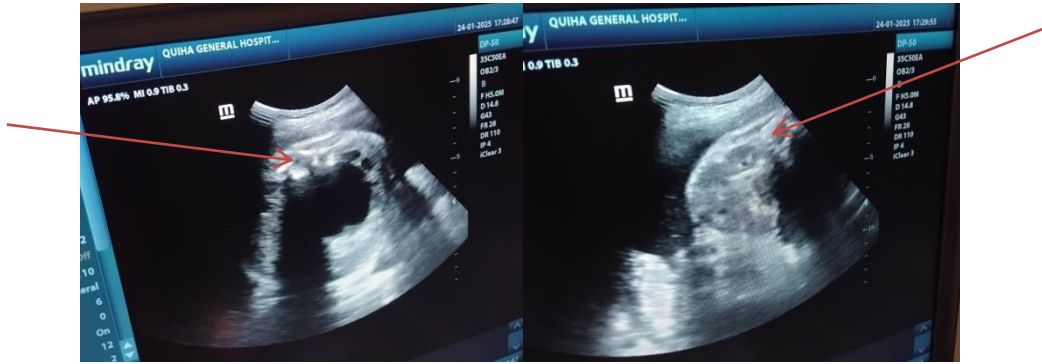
Ultrasonographically detected unilateral polycystic kidney disease (right) of fetus in 22 years old multigravida pregnant woman at 40 weeks of gestation in Quiha general hospital, 2025.
